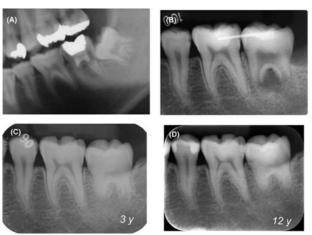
External root resorption (patient 17 years). (A) - view around the site of the procedure; (B) - X-ray after transplantation; (C) - three years later (positive electrical pulp testing, low root development); (D) - twelve years after autotransplantation [55]
